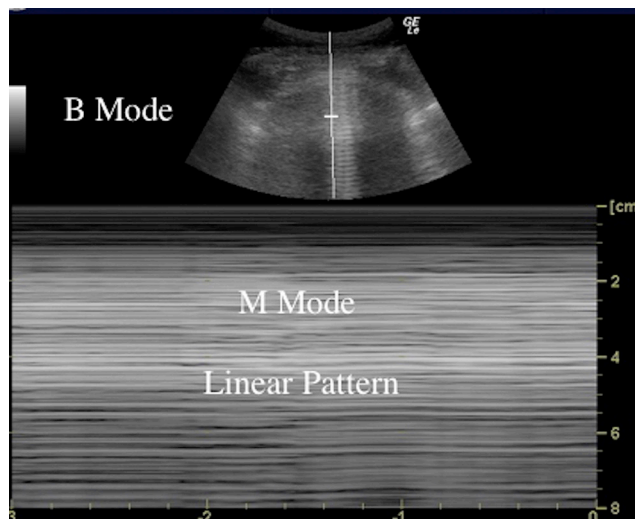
Ultrasonography B and M mode depiction of a pneumothorax. Note the 'bar-code' appearance of the M mode image (linear array).¹³
